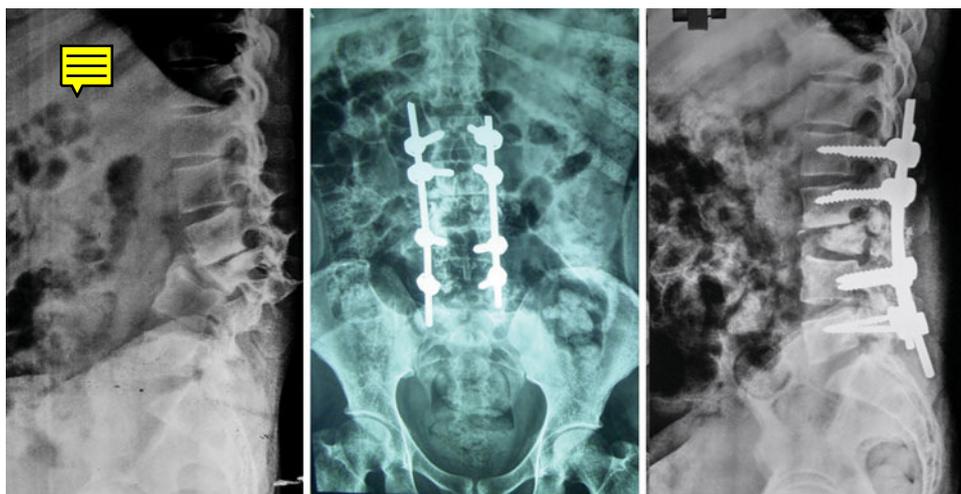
Schuerman's kyphosis of the dorsolumbar spine in a 24-year-old male patient. Postoperative X-rays showing a satisfactory correction
